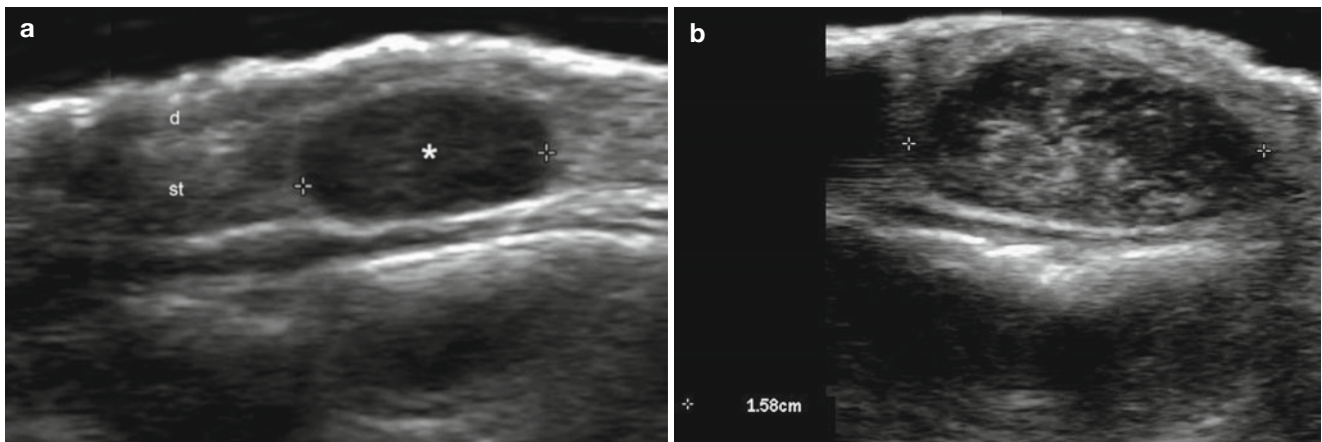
(a–e) Schwannoma. (a, b) Grey scale ultrasound images (longitudinal view) of the left retroauricular region (a basal and b 1-year follow-up) shows a well-defined, oval-shaped hypoechoic nodule that becomes more heterogeneous and increases in size in the follow-up examination (from 0.74 to 1.58 cm). Notice that the nodule is located in the subcutaneous tissue in the basal ultrasound image but bulges into
